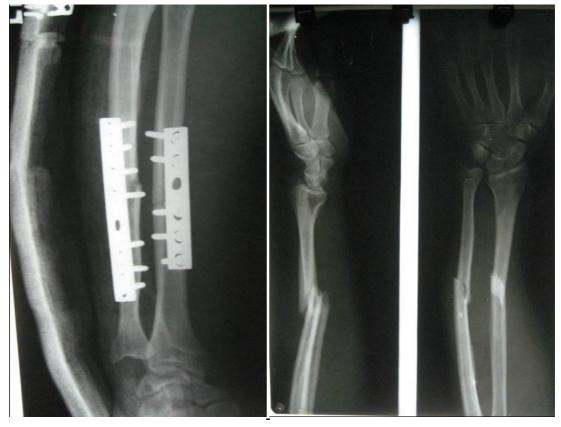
Preoperative and postoperative radiographic image
